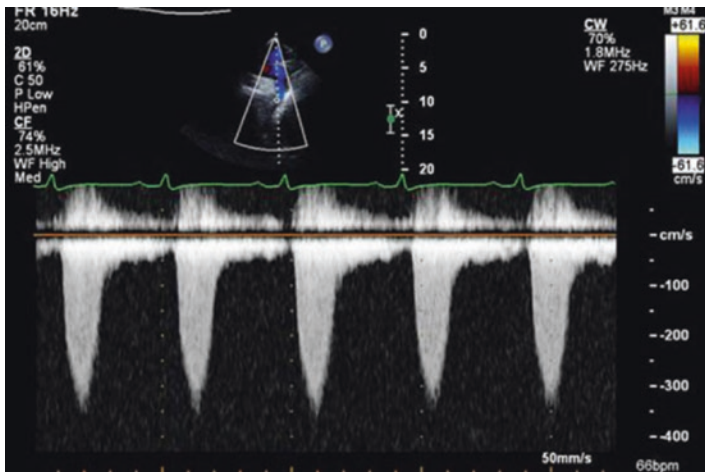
2D echocardiogram, Doppler profile of antegrade diastolic flow in the abdominal aorta (Adopted with permission from [2])
